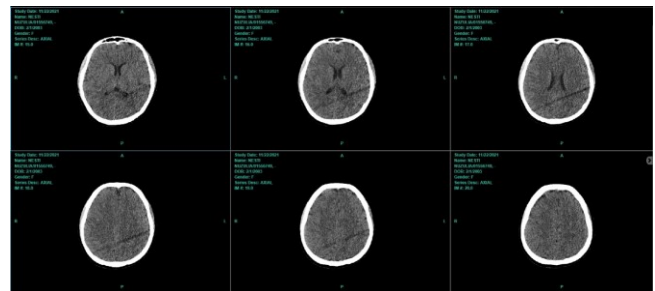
CT scan of the head non-contrast axial section
